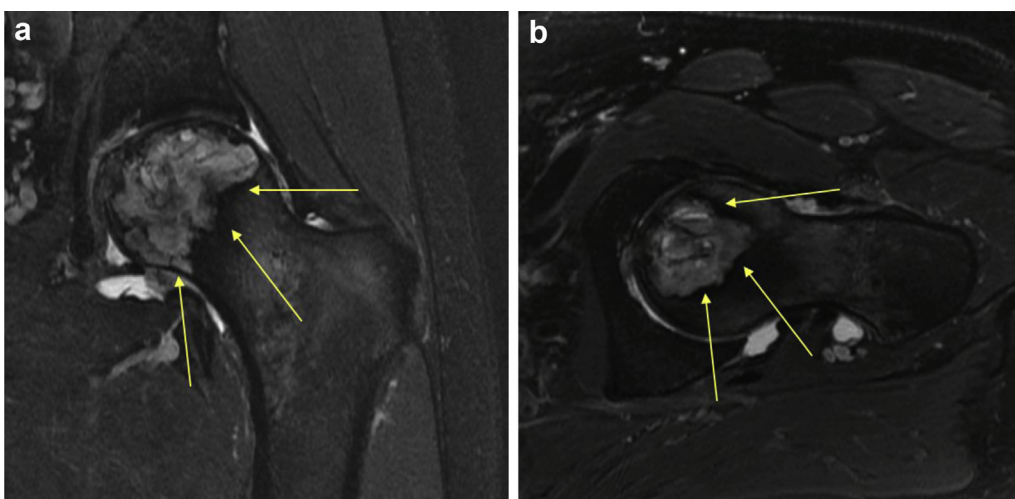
(a) Preoperative MRI (magnetic resonance imaging). (b) Preoperative MRI. MRI shows a hyperintense heterogeneous lesion within the femoral head (arrows) with violation of the subchondral plate and associated femoral head fracture.
